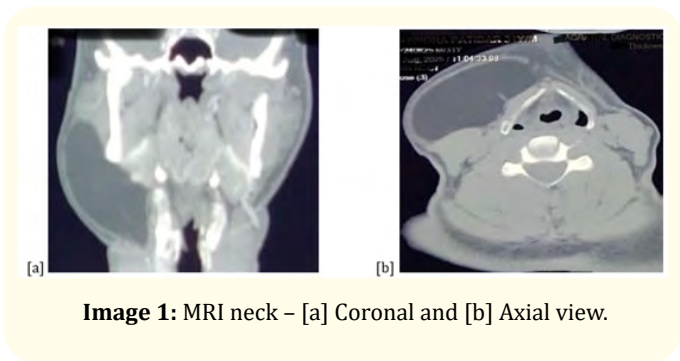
MRI neck – [a] Coronal and [b] Axial view.
